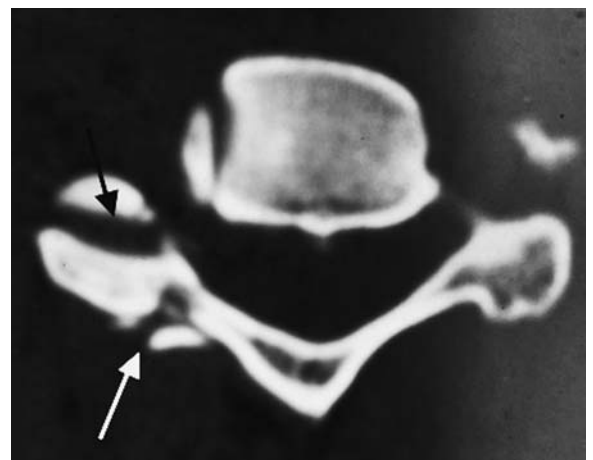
Pillar fracture. Axial CT image. The fracture line (*white arrow*) is confined to the articular mass. Note the unilateral facet subluxation (*black arrow*)
